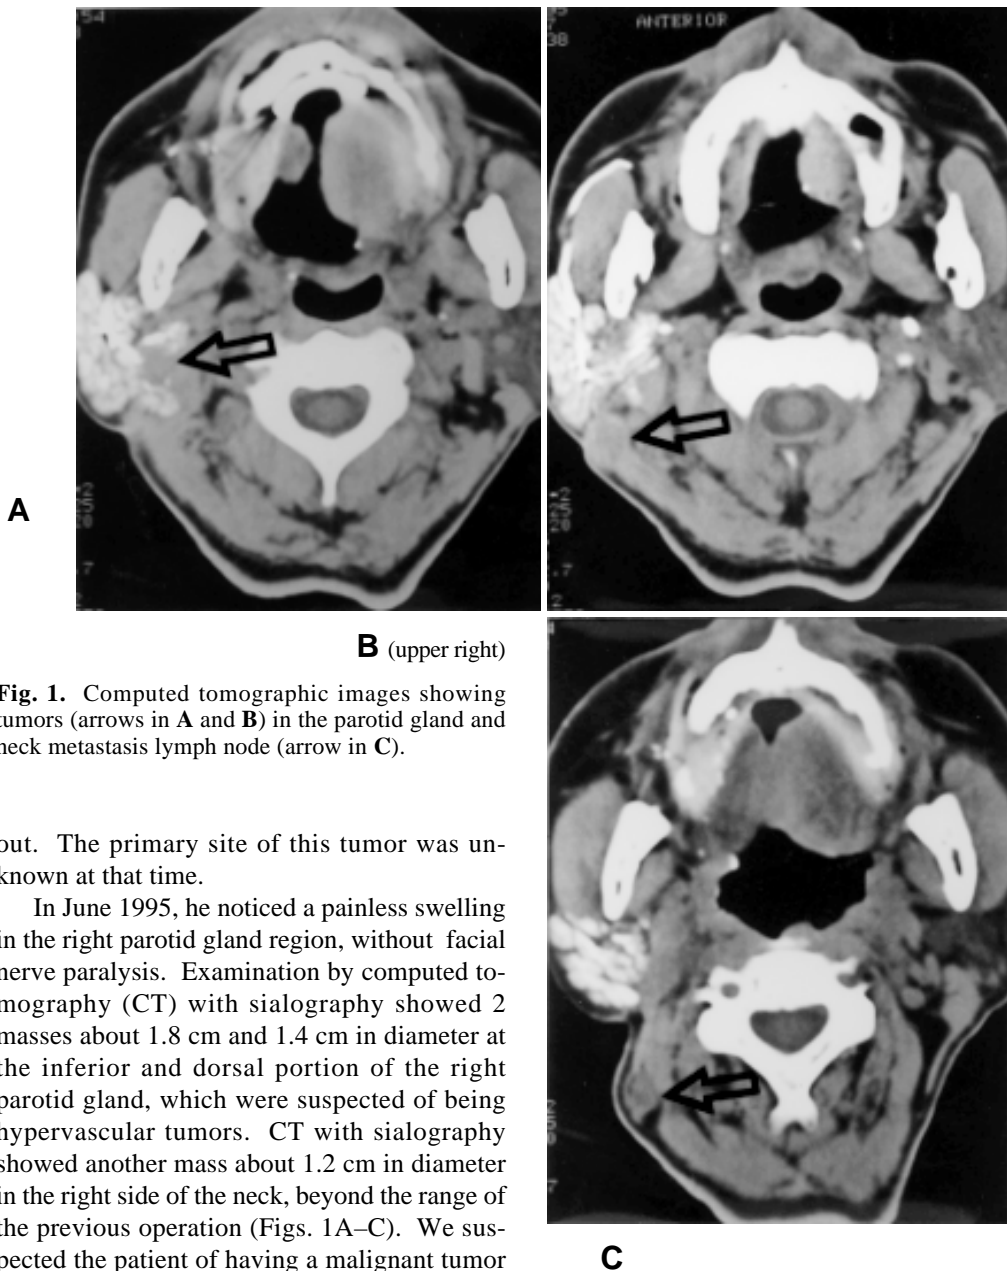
Computed tomographic images showing tumors (arrows in A and B) in the parotid gland and neck metastasis lymph node (arrow in C).
